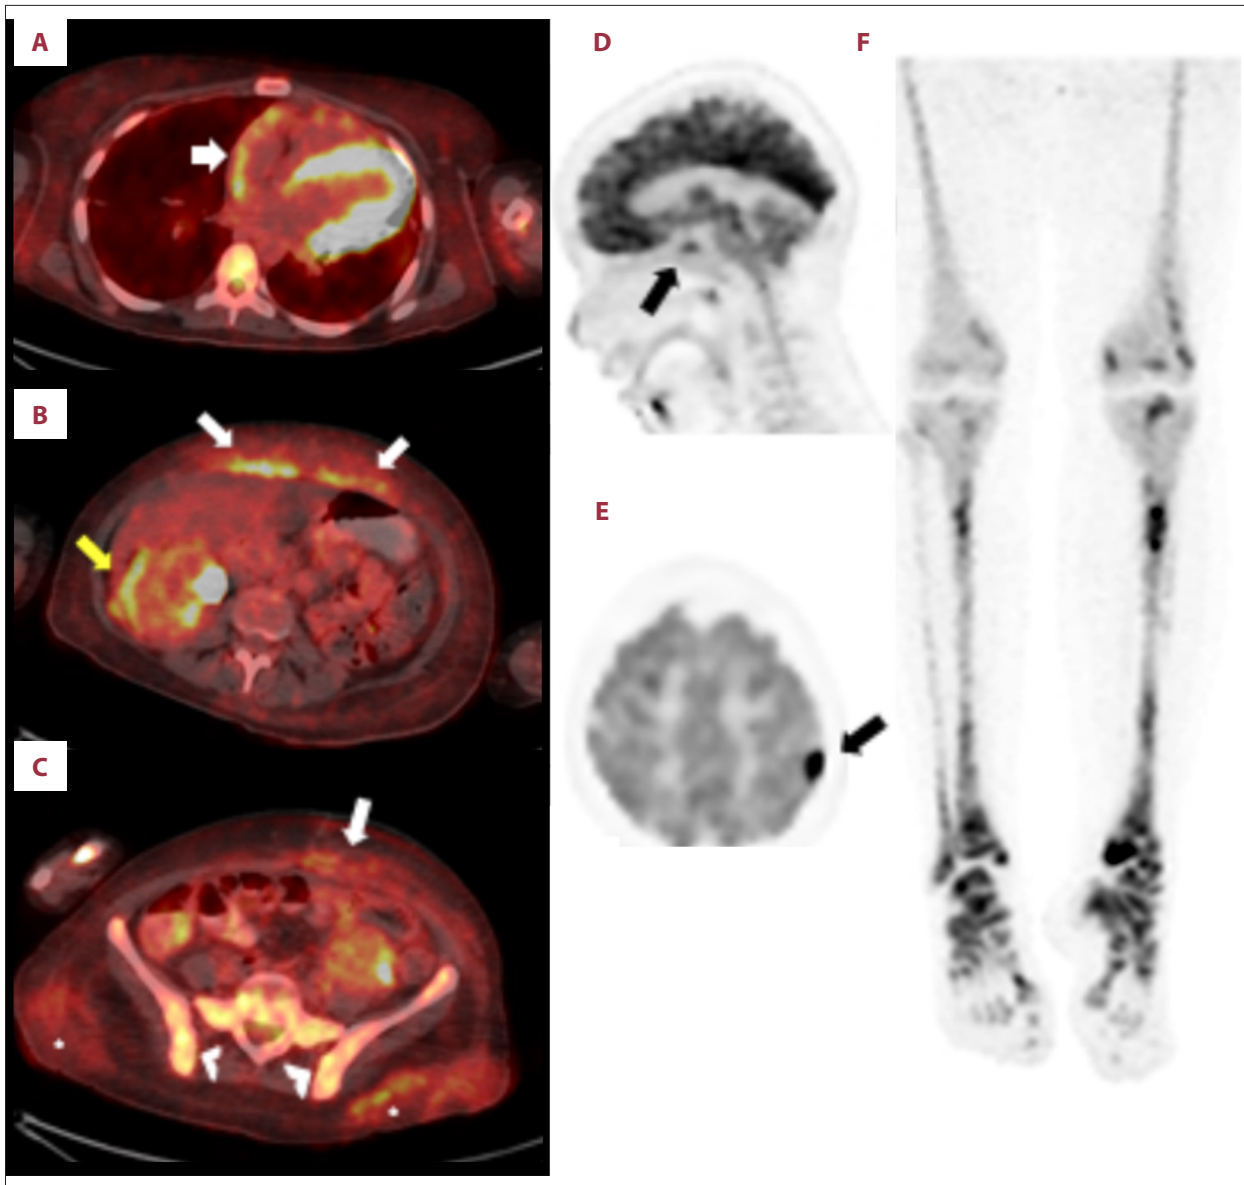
Baseline FDG PET-CT. (A) Transaxial fused image at the level of the heart shows moderate pericardial hypermetabolism overlying the right atrium (arrow). Transaxial fused images at level of abdomen (B) and pelvis (C) show hypermetabolic (SUV 7.7) right perinephric soft-tissue infiltration (yellow arrow), heterogeneous hypermetabolism in sacrum and iliac bones (arrow heads), and fat stranding and soft-tissue thickening in anterior abdominal wall (SUV 13.4) (white arrows) and bilateral gluteal regions (stars). (D) Sagittal brain PET image shows hypermetabolic pituitary lesion. (E) Transaxial brain PET image shows hypermetabolic dural-based extra-axial left parietal lesion (SUV 26.5). (F) Anterior maximum-intensity projection (MIP) image of lower extremities shows areas of heterogeneous hypermetabolism in multiple bilateral bones related to symmetrical metaphyseal and diaphyseal sclerosis (not shown).
